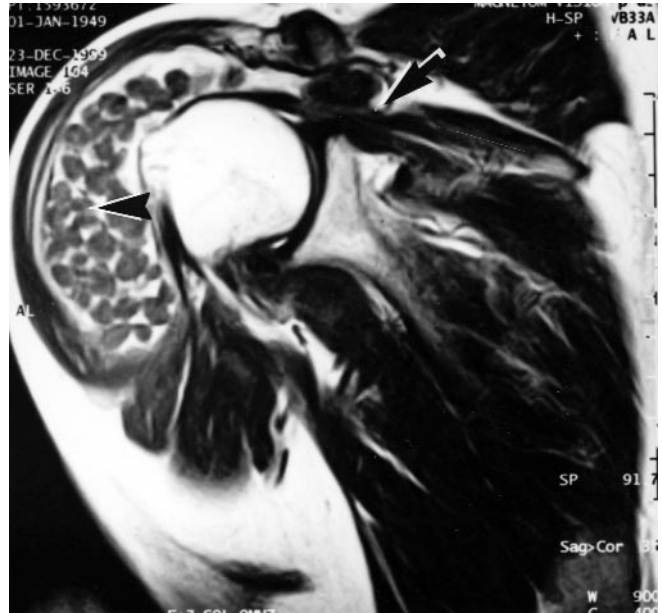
MRI of the left shoulder showing synovial chondromatosis in the subacromial bursa (arrowhead), impingement syndrome in the rotator cuff, and partial rupture (arrow).
